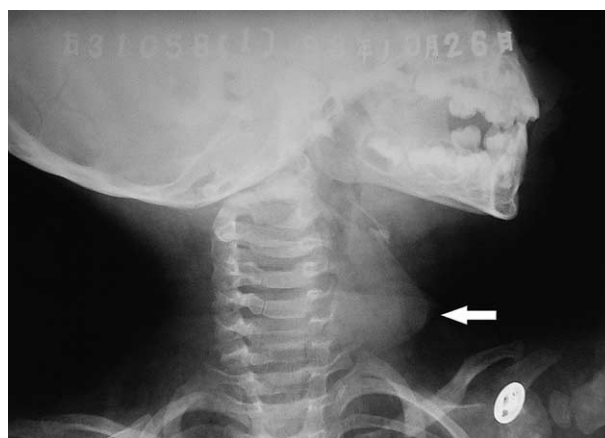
A lateral neck radiograph showing the soft tissue mass in anterior neck region.
